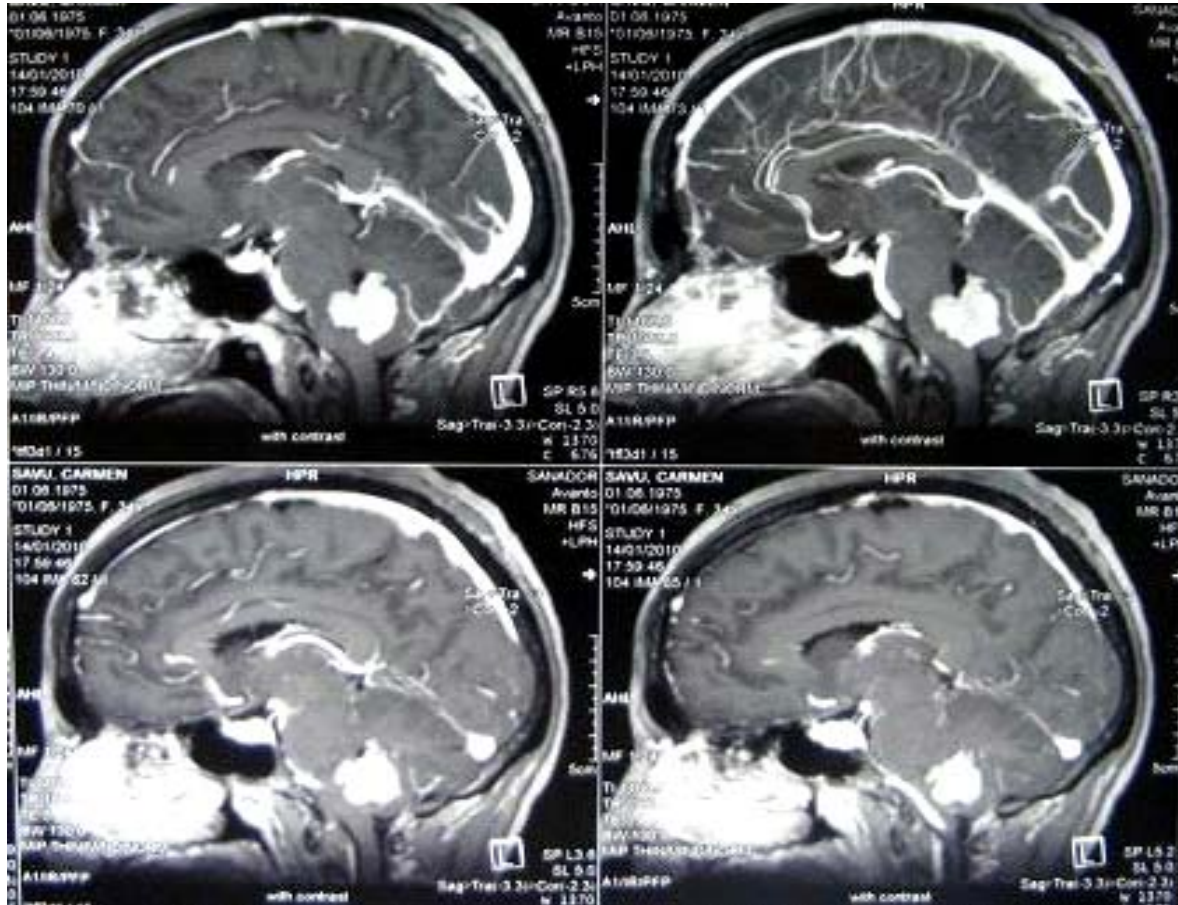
Preoperative MRI-scan (sagittal incidence)
